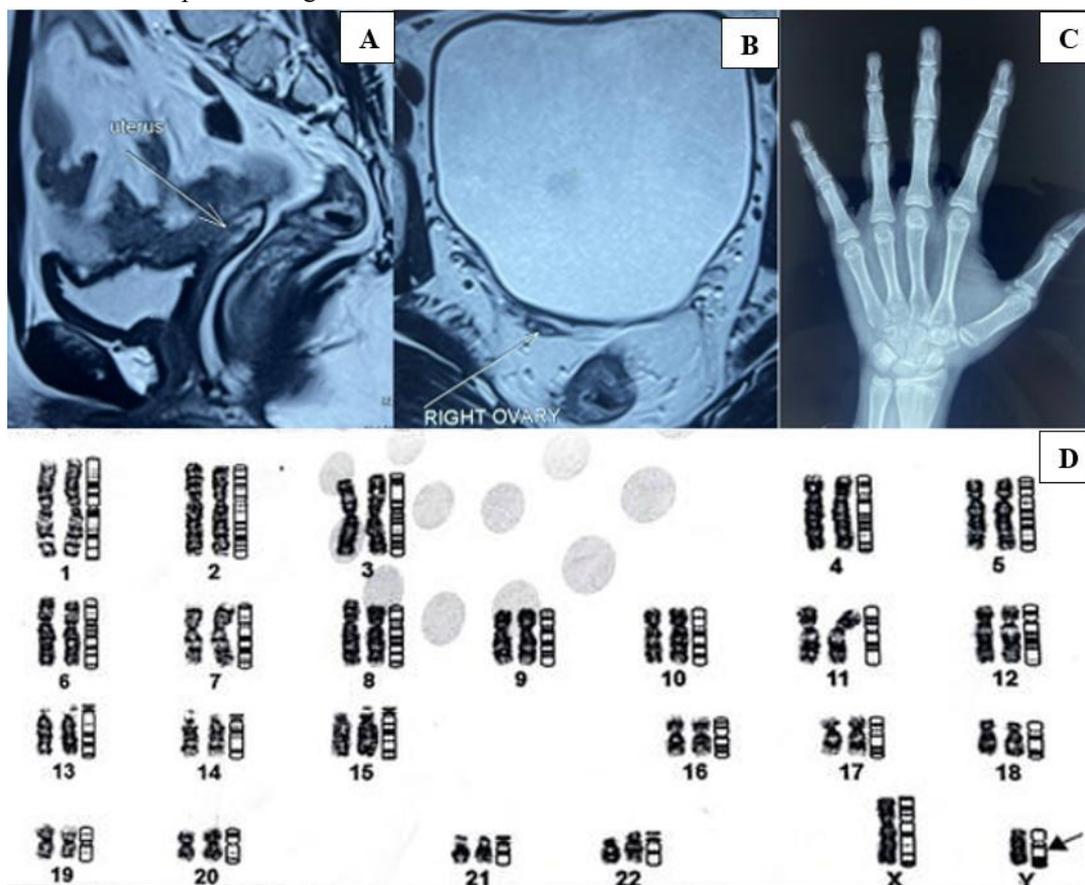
Radiological and cytogenetic evaluation showing (A) pelvic MRI sagittal section demonstrating an infantile uterus, (B) pelvic MRI axial section showing the right ovary, (C) hand radiograph with normal skeletal anatomy and (d) karyotype analysis revealing a 46, XY chromosomal pattern.
